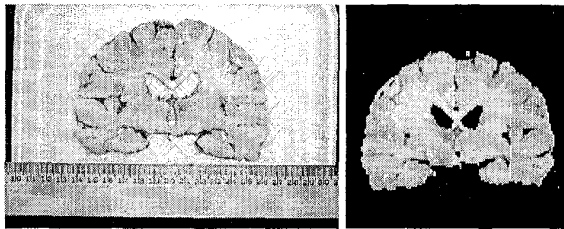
Photograph of a postmortem slice (left) and its gray-scale version after removal of the background (right). The gray-scale image was flipped left-to-right to match MRI orientation.
